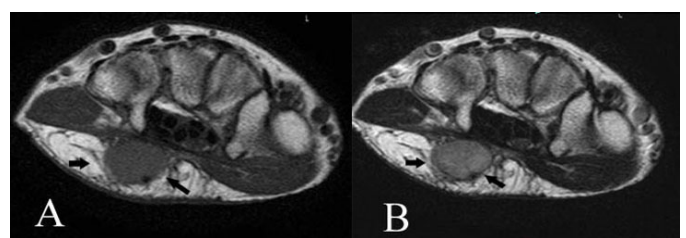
Case 2. Angiofibroma of soft tissue in the palm. Axial T1-weighted MRI (TR/TE=529.63/23) demonstrates a well-circumscribed subcutaneous mass adjacent to the palmar aponeurosis with homogeneously slightly high signal intensity (arrows) (A). Corresponding axial T2-weighted image (TR/TE=2652.90/83.85) reveals a mass to be inhomogeneously high signal intensity (arrows) (B).
